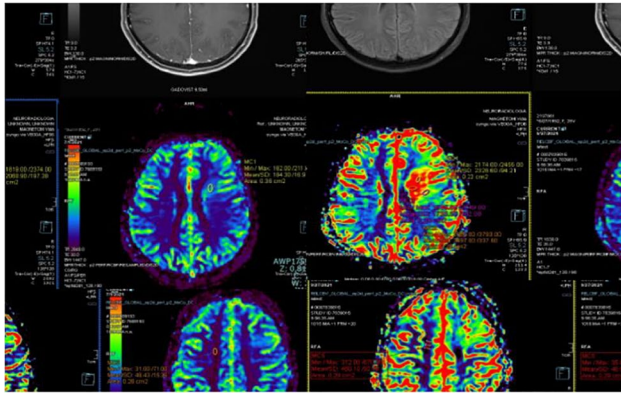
baseline (fig. 2A) and follow-up MRI (fig. 2B) in a 29-year-old patient. Progressive disease.
